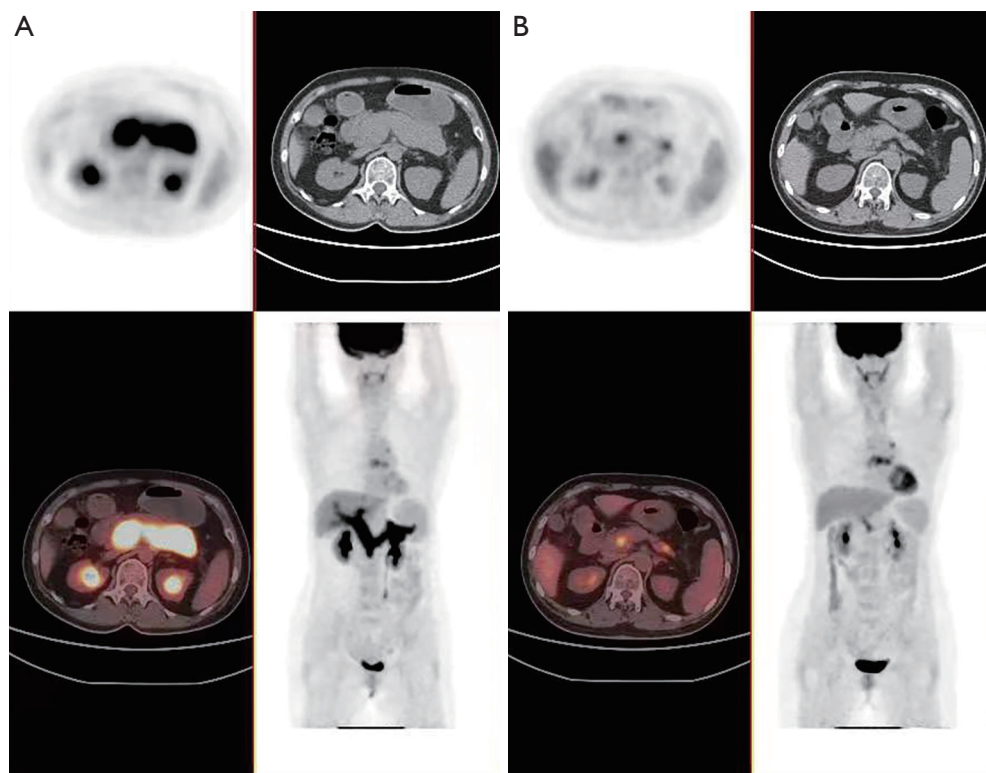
Comparison of PET-CT images before and after neoadjuvant chemotherapy. (A) Before chemotherapy. (B) After chemotherapy, showing a significant reduction in the size of the original portal vein tumor thrombus. PET, positron emission tomography; CT, computed tomography.
